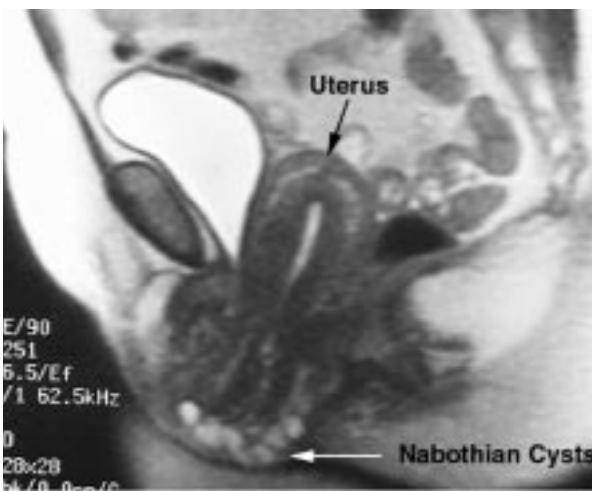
Pelvic floor MRI: hysterocele
